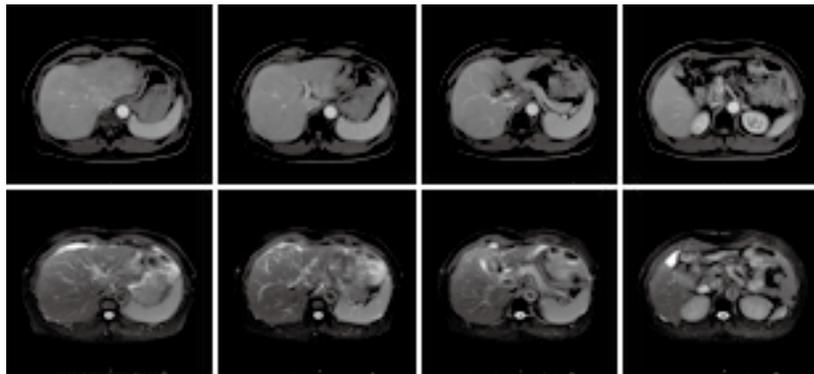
MRI taken April 2018. No apparently enlarged hepatic portal lymph nodes were observed
